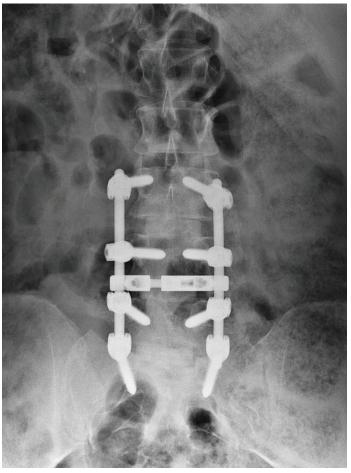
Post-operative Anteroposterior View X-ray Following a TLIF at L3/L4, L4/L5, and L5/S1.
